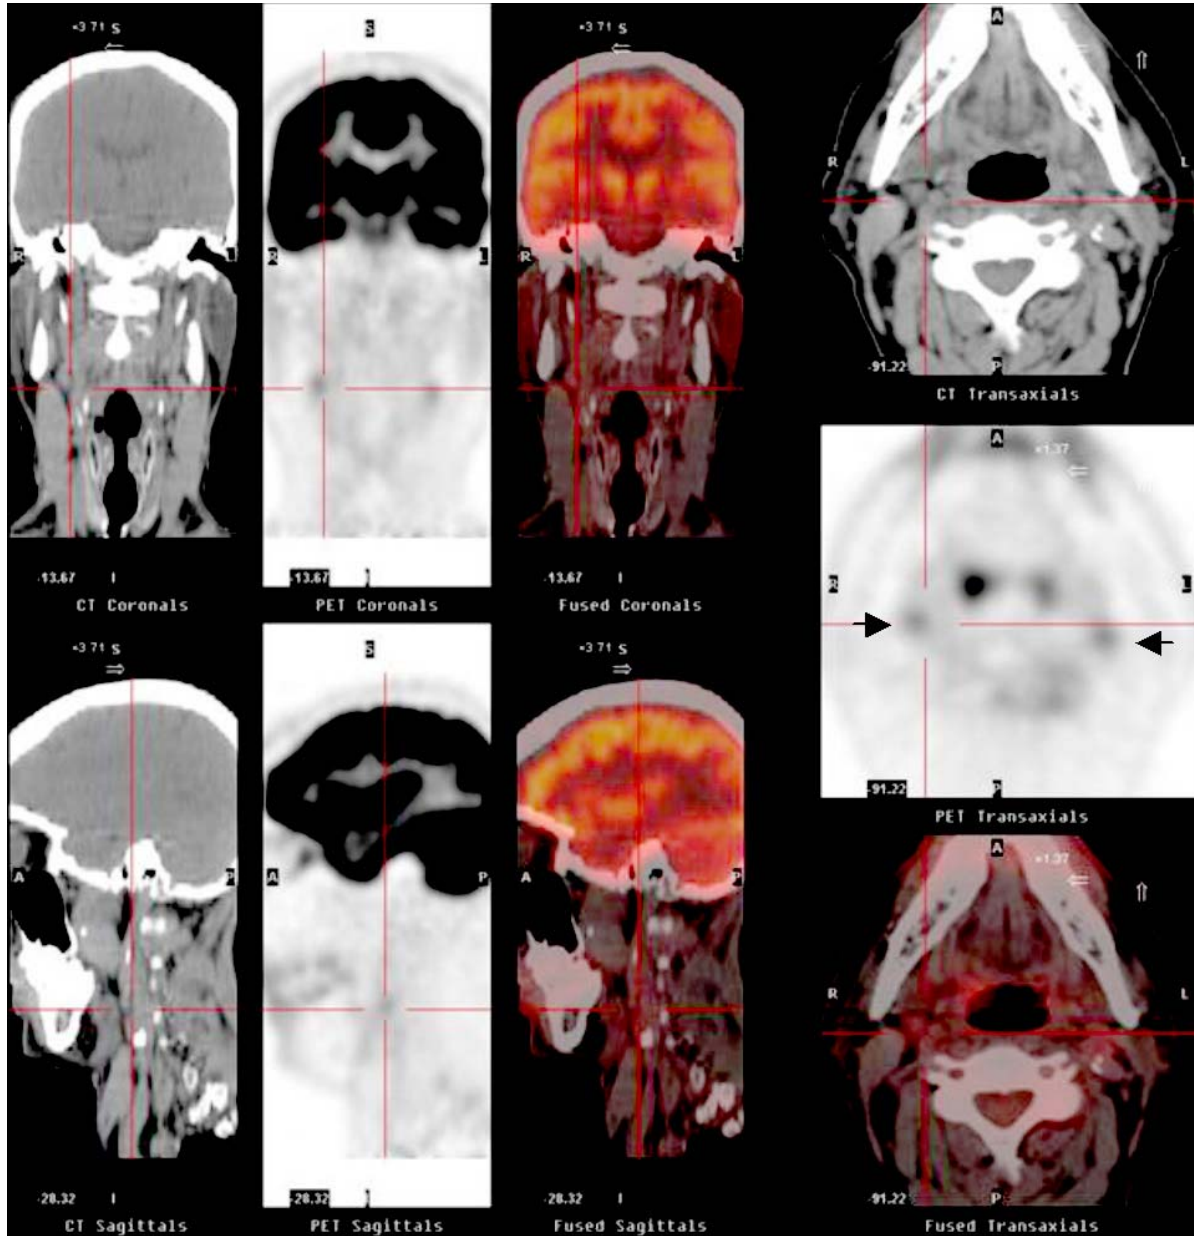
Fluorine-18 fluorodeoxyglucose PET (18-FDG-PET) in a patient with a preocclusive left internal carotid stenosis and 50% right internal carotid stenosis. Arrows demonstrate inflammatory infiltrates and high carotid plaque metabolic activity *in vivo* corresponding to increased 18-FDG plaque uptake.
